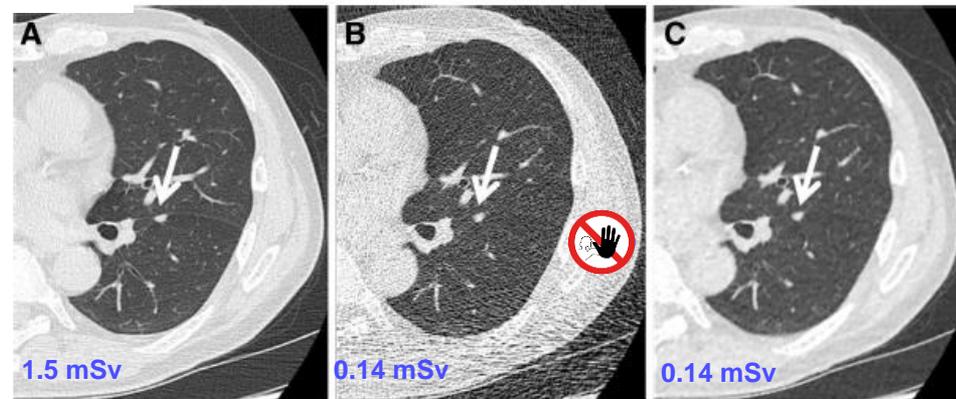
63-year-old man with a 7-mm solid nodule in the right upper lobe detected by lung cancer screening. a Low-dose CT (LDCT) image reconstructed with filtered back projection (FBP). The *arrow* points to the nodule. b Ultra-low-dose CT (ULDCT) image reconstructed with FBP. While identification of the pulmonary nodule is
